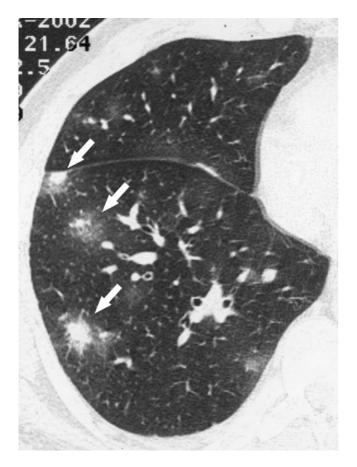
Simple pulmonary eosinophilia (Loeffler syndrome) in a 42-year-old man with peripheral eosinophilia (53.5% of eosinophils in the peripheral blood). Thin-section CT shows multiple small nodules (arrows) with a surrounding halo of ground glass opacity in the right lower lobe.
